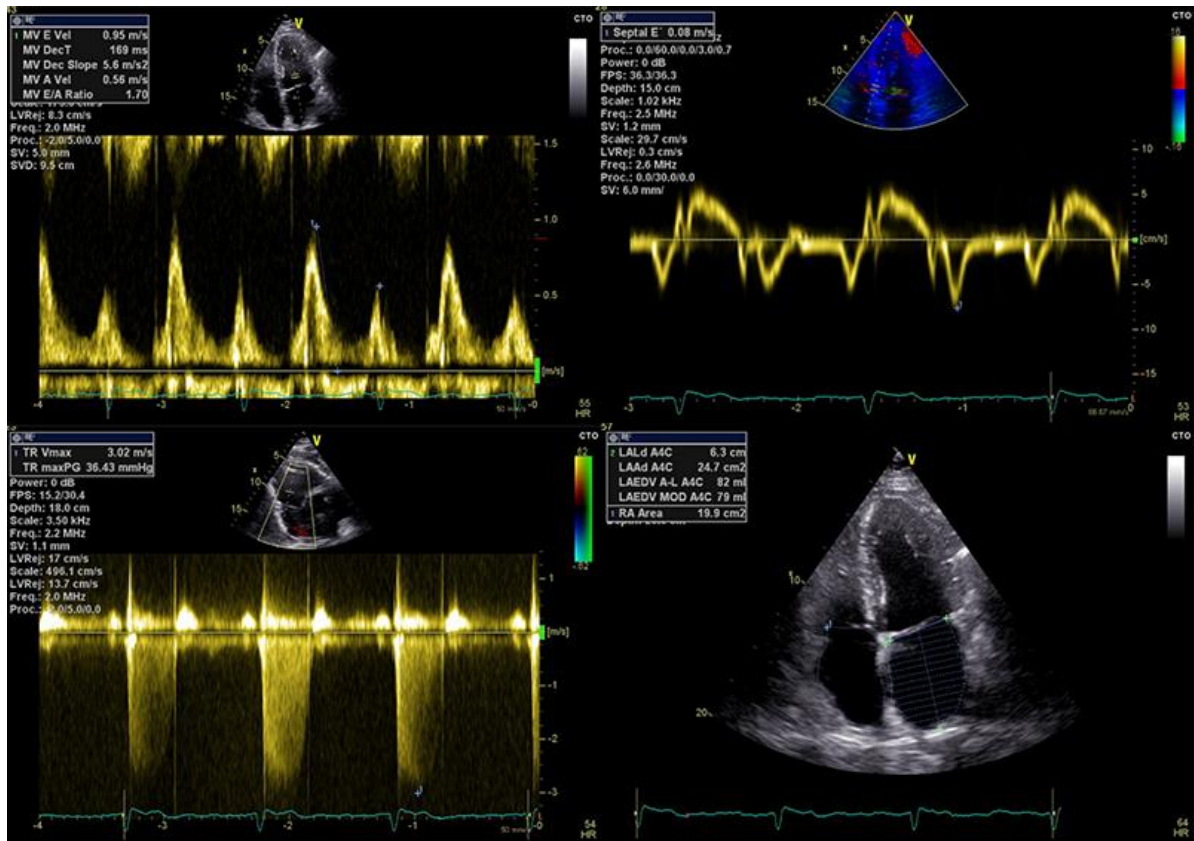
How the main variables to assess diastolic parameters are measured with echocardiography. *Top left:* Measurement of E-wave and A-wave, with calculation of E/A ratio. *Top right:* Measurement of septal e' (lateral e' is measured in a similar way, but on the lateral portion of the myocardium). *Bottom left:* Measurement of TR, as detailed in the previous chapter. *Bottom right:* Measurement of LA volume and calculation of LAVI based on the patient's body surface area.
